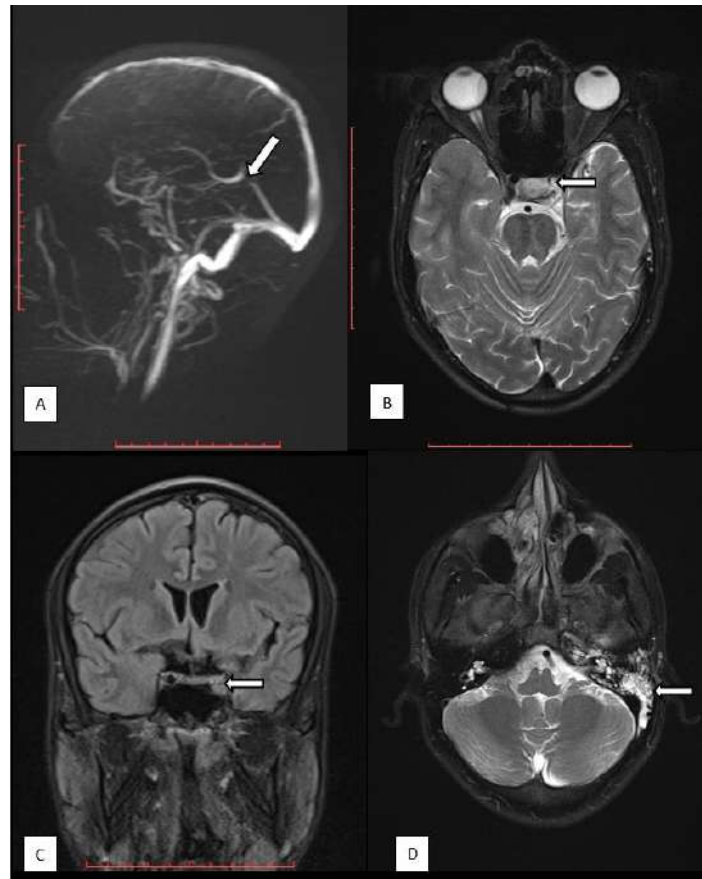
Non enhanced MRI images in a case of 35 year old male patient presenting with giddiness and visual disturbances, Non enhanced MRI with pulse sequences images acquired at selective sections through the cerebral venous sinuses & left mastoid were acquired (A) 3D MIP MRV depicting focal non-visualization of the straight sinus near confluence of vein of Galen (arrow) into it suggestive of venous thrombosis. Axial T2TSE (B) & coronal FLAIR (C) images show absence of normal flow void involving left internal carotid artery(ICA)(arrow) at the level of cavernous sinus in both T2TSE & FLAIR images with associated fluid signal intensity in the left mastoid air cells shown in T2 TSE (D) suggestive left cavernous ICA thrombosis secondary to left mastoiditis (arrow).
